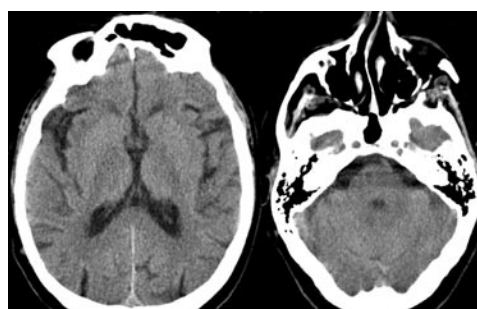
Cranial computed tomography of the patient 2, it does not show relevant findings.
